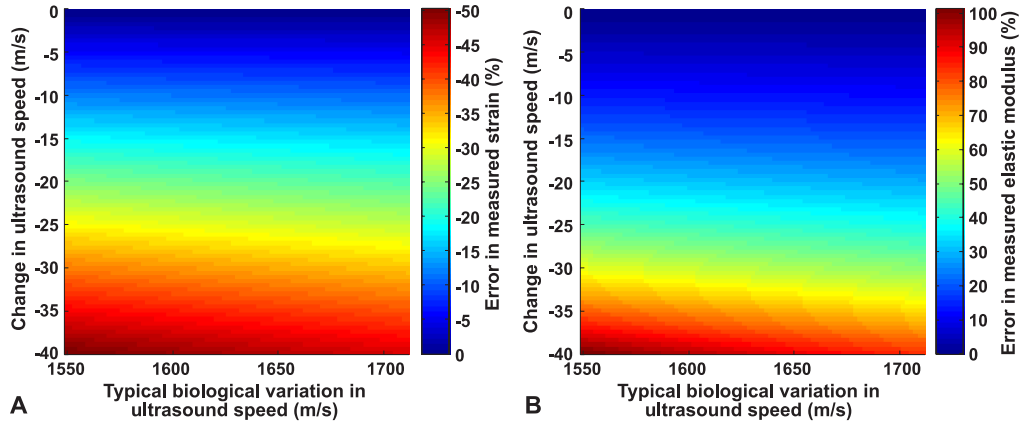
Relative error in mechano-acoustically measured strain (A) and in elastic modulus (B) as a function of the typical variation of ultrasound speed in cartilage and the ultrasound speed change during an instantaneous 5% compression (IV). The typical change in the ultrasound speed, -25 m s^{-1} , during instantaneous compression induced an error of -30% in strain and $+40 \%$ in elastic modulus.
